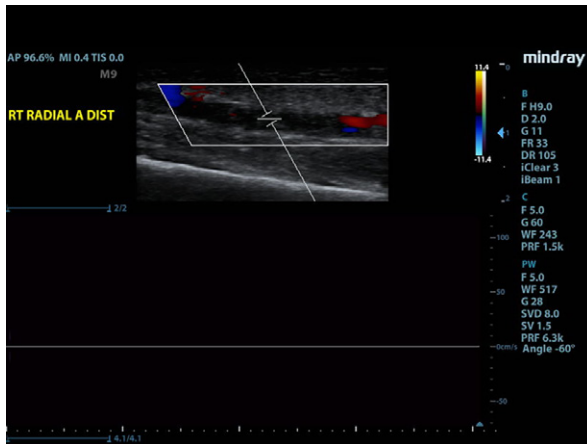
Duplex ultrasonogram shows thrombotic occlusion of the right radial artery (top), and no flow on pulsed-wave Doppler (bottom).
